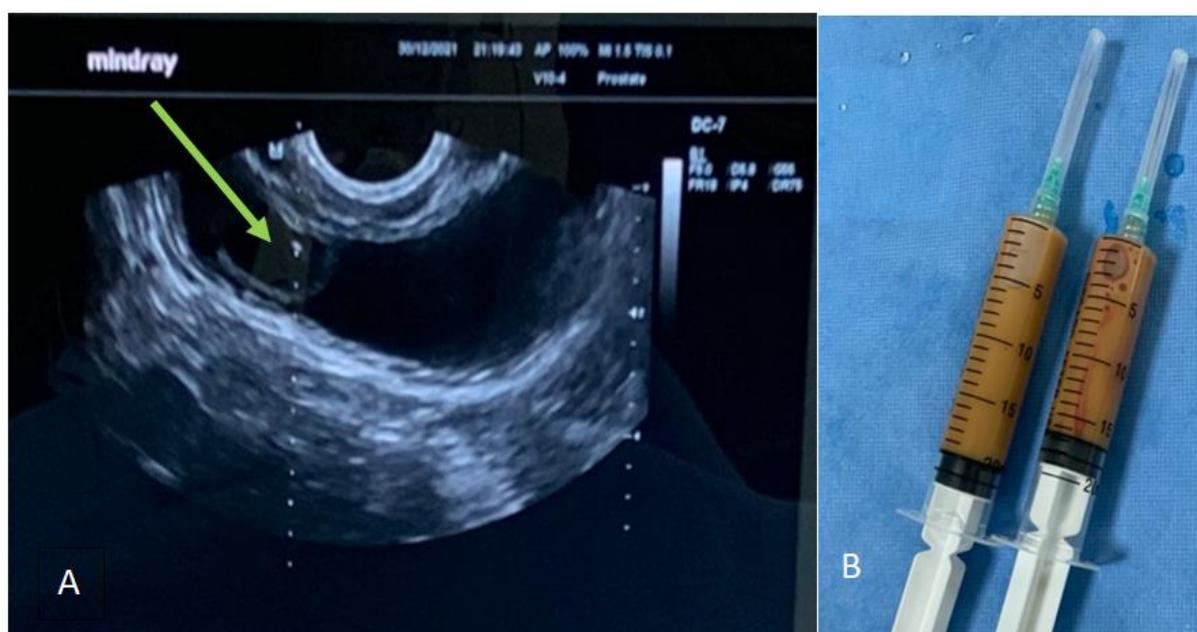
(A) Endorectal ultrasound images of the bladder, showing a cystic lesion protruding into the vesical lumen (red arrow) on the right side with non-visualization of the right seminal vesicle; (B) Buff-yellow appearance of the puncture fluid
